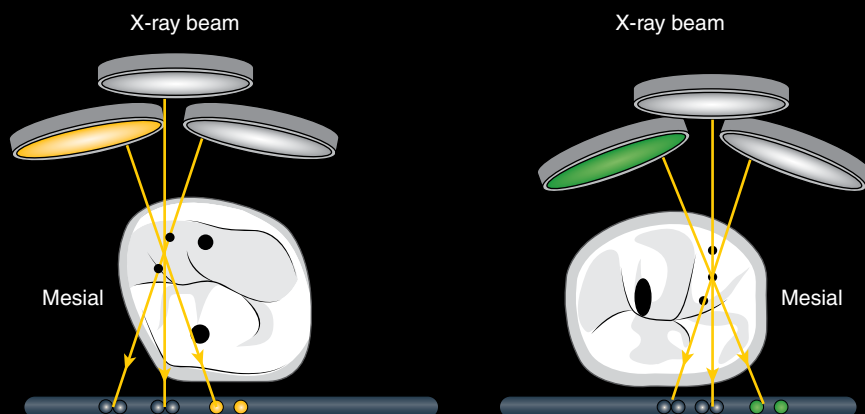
Parallax technique. Note how horizontal shift of the radiograph can aid in separation of the root canals.
